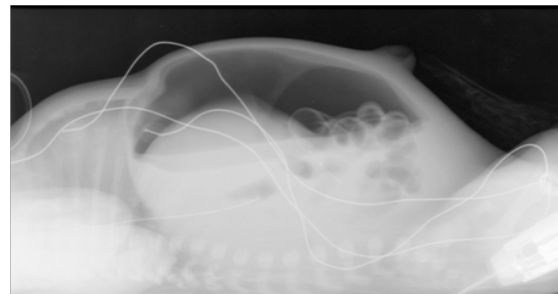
Profile tangential chest radiograph showing free intra-abdominal air, as well as air delimitating the intestinal wall both internally and externally (Rigler's sign).
